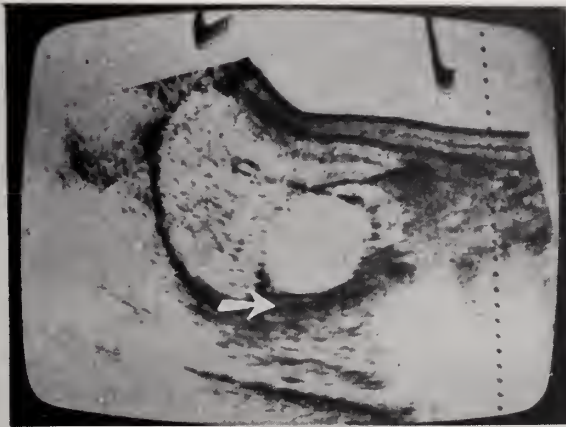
a) Renal cyst sonographically diagnosed by a sonolucent (echo-free) mass with distinct margination, refractive edge-shadowing (arrowhead) and distal acoustic enhancement (arrow). b) Cystogram: Water soluble (Conray-60) contrast injected to study margins of lesions.
